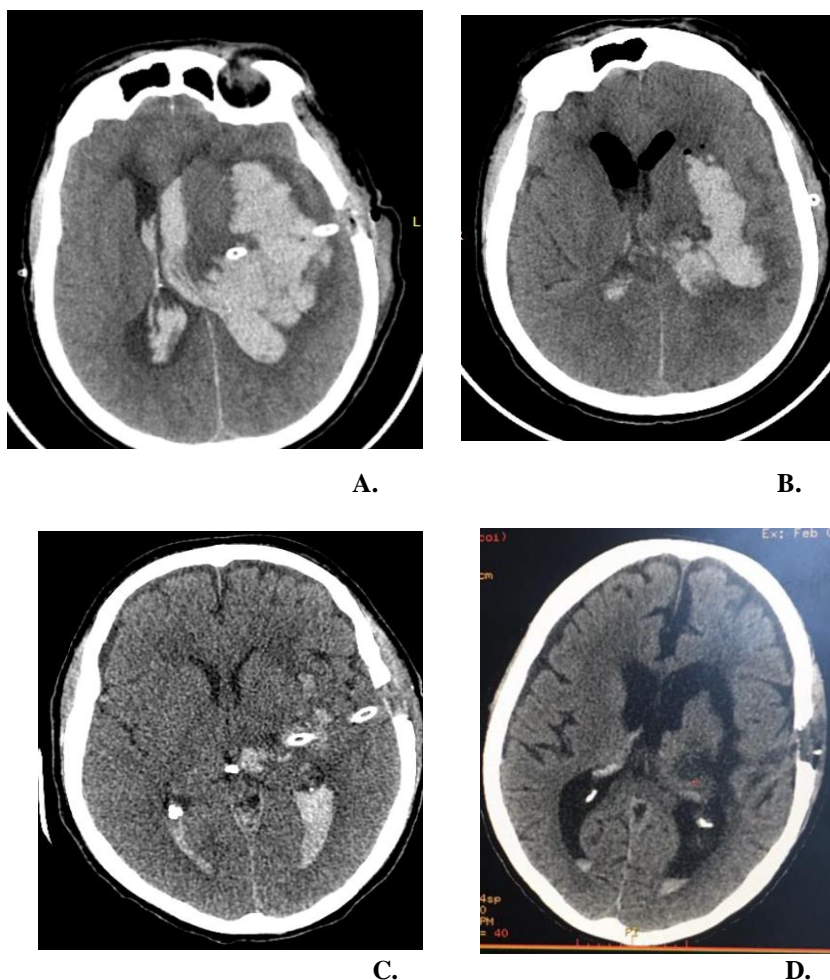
CT scan before and after the administration of the tPA.
